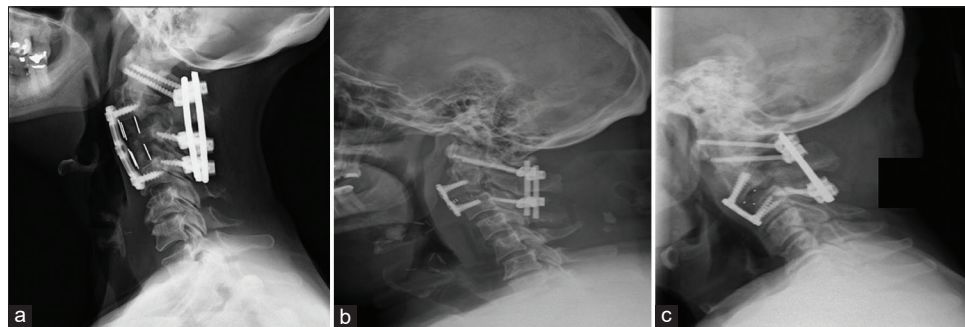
C-spine X-ray [lateral] shows (a) C3 corpectomy with C2-4 anterior and C1-C4 posterior arthrodesis, (b) reduction of C2-3 with C1-C3 posterior arthrodesis, (c) reduction of C2-3 with C1-C3 posterior arthrodesis.
